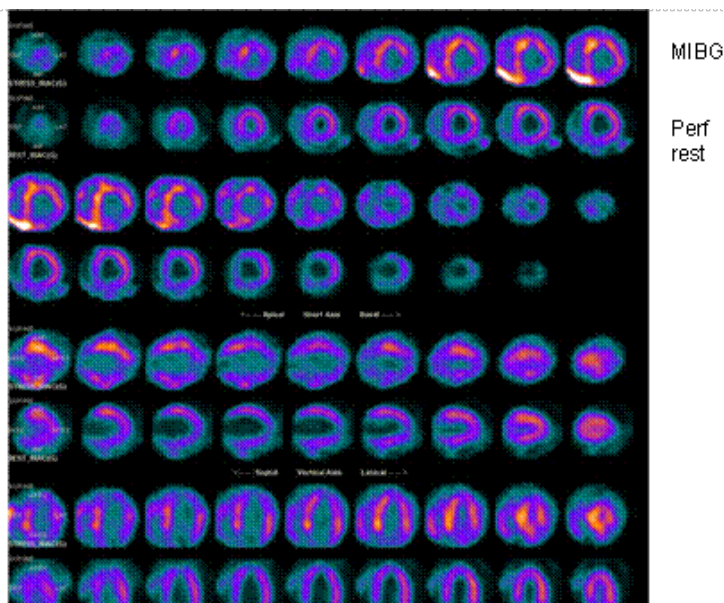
Comparison of Iobenguane and rest perfusion ^{99m}Tc tetrofosmin SPECT images in patient O.F.: a severe reduction of MIBG and TC-99 uptake in the apex emerged; the reduction of myocardial uptake of Iobenguane in the inferior wall appear to be more severe than perfusion, describing a denervation pattern after PTCA similar to images obtained in diabetic patients after revascularization.
